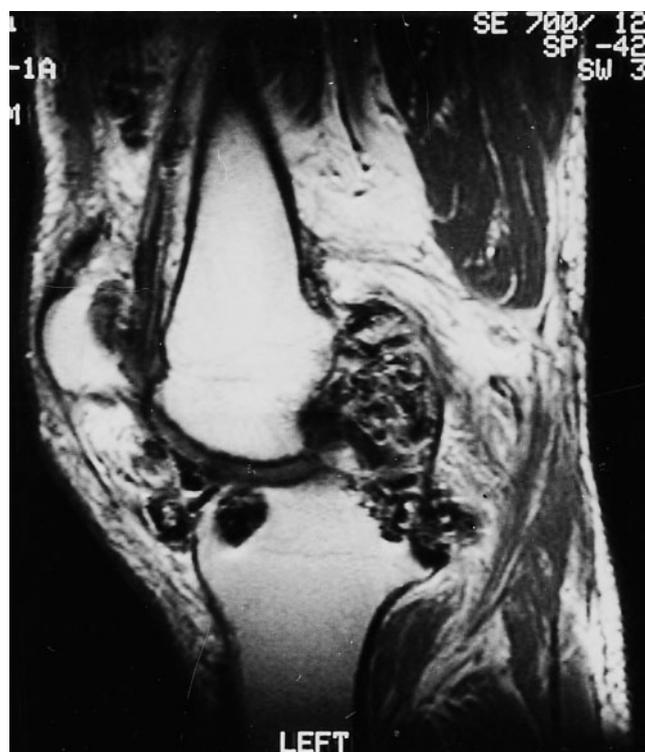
Sagittal T₁-weighted MRI after gadolinium injection. Low signal nodules, indicating haemosiderin deposits, in the knee joint and within the erosions. Enhancing synovium surrounding the haemosiderin deposits indicates synovitis.
